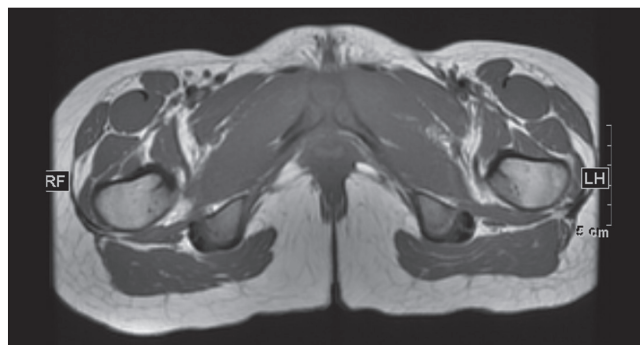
Magnetic resonance image of pelvis and upper thighs (AX T1 weighted)
